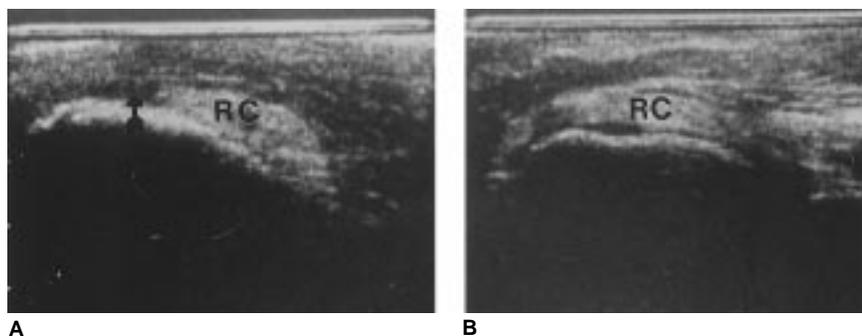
Longitudinal sonograms of both shoulders. A, Image of the right shoulder depicts a full-thickness tear (arrow) of the rotator cuff (RC). B, Image of the left shoulder shows an intact rotator cuff.
